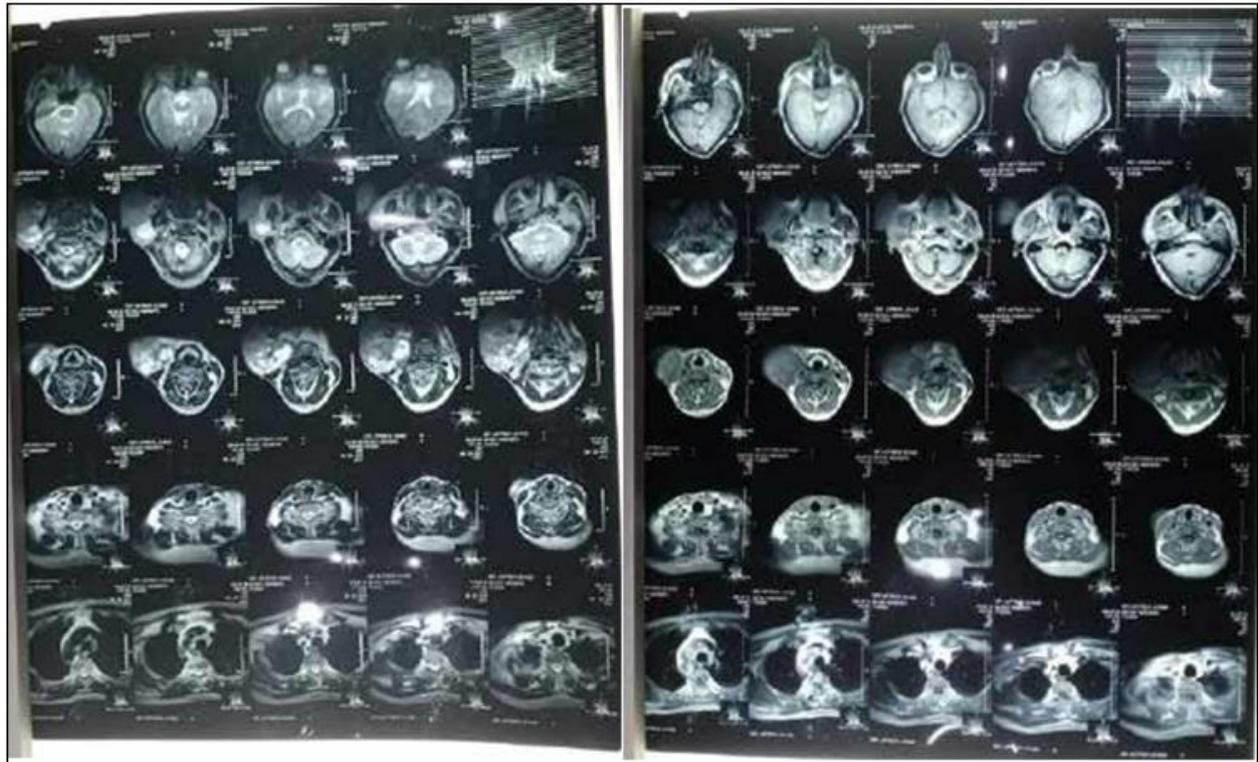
MRI Face & Neck with Contrast
